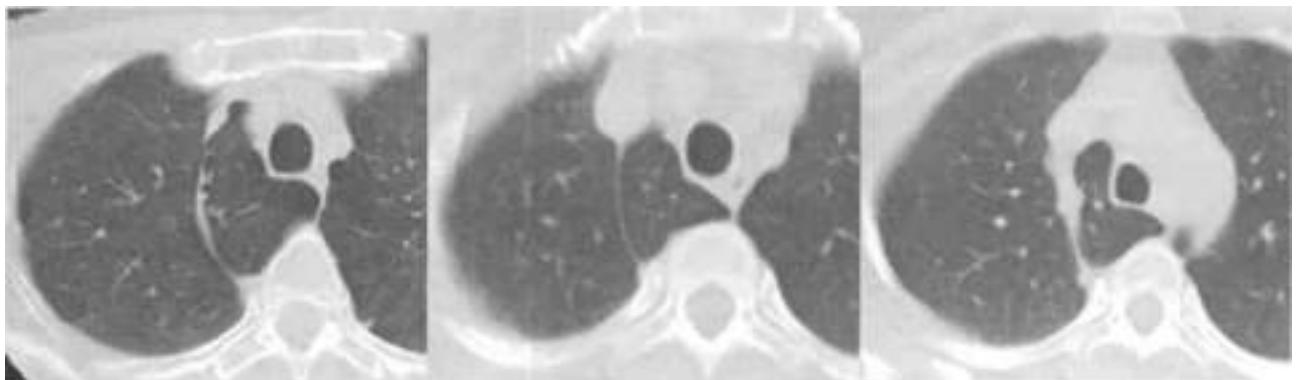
CT variants of the accessory lobe of the unpaired vein.
